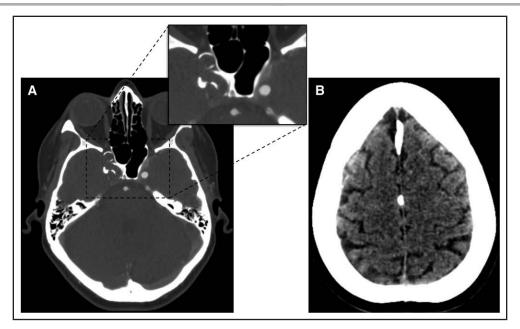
Cerebral images of patient ID-5 with a heterozygous ABCC6 variant of uncertain significance. A, Axial brain computed tomography (CT) angiography showing occlusion of a dysplastic and calcified right internal carotid artery. B, Axial brain CT scan showing calcifications of the falx cerebri.
